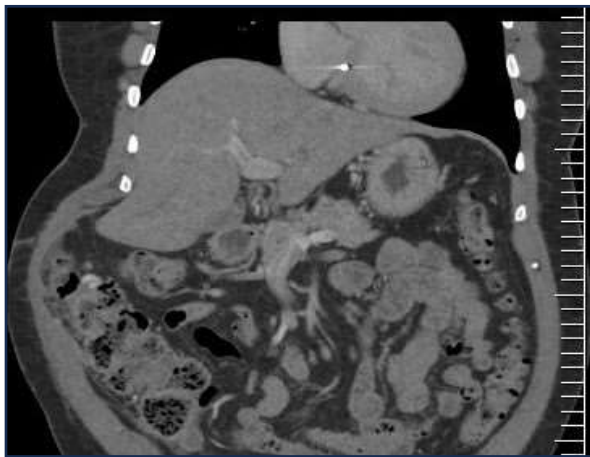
Follow-up CT abdomen showed right atrial micro-coil.
